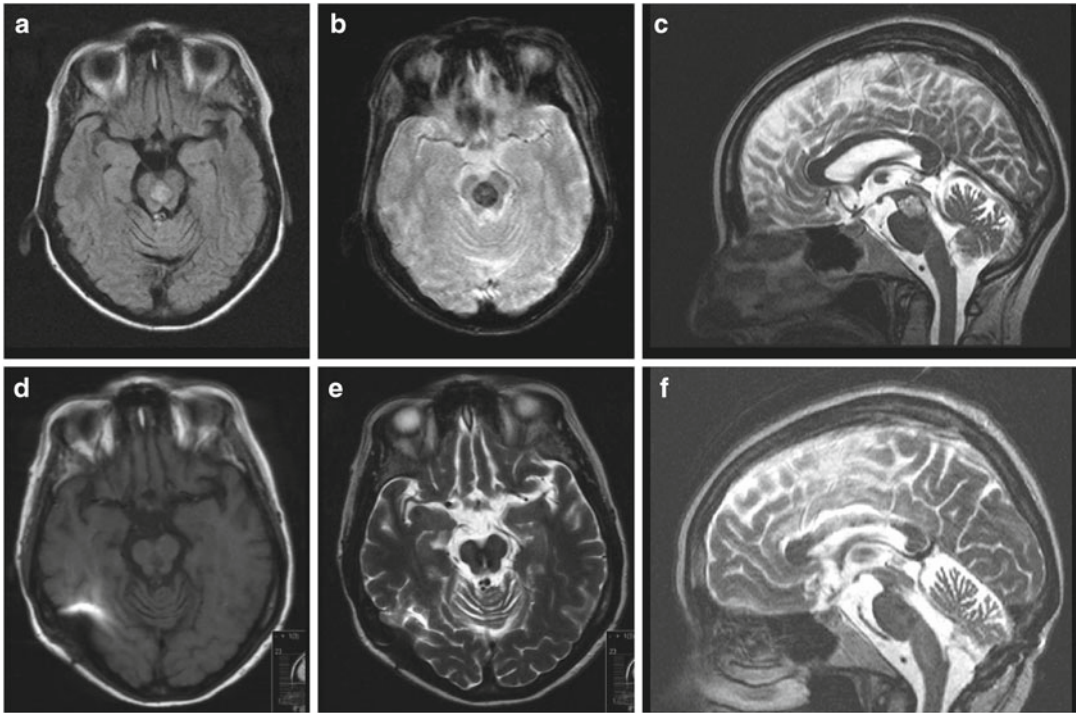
Pre- (a–c) and postoperative (d–f) magnetic resonance imaging scans of a patient with mesencephalic cavernous hemangioma. (a) T1-weighted axial image of the cavernoma. (b) gradient spin echo axial image showing the hemosiderin deposit. (c) T2-weighted
